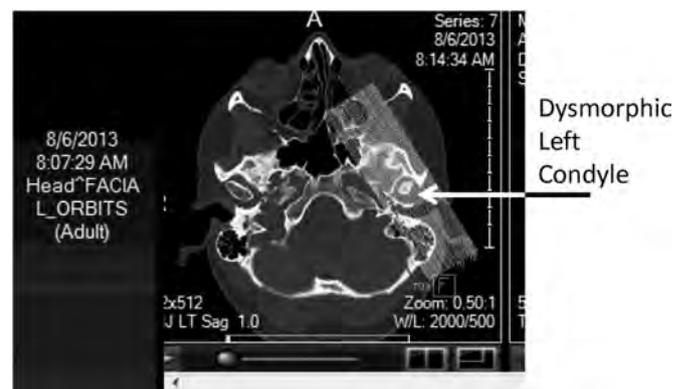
Dysmorphia of the mandibular condyle in an 18 y old Ehlers Danlos Type III patient (a genetic cartilage impairment). This CT-scan allows studying the impairment of the mandibular condyle. Patient misdiagnosed for years: repetitive ankle luxations and temporo-mandibular pain with bruxism, presence of daytime fatigue, some degree of daytime sleepiness, difficulty to concentrate, and mandibular pain. Results of polysomnography: apnea–hypopnea index-AHI = 16.9 events/hour of sleep, lowest oxygen saturation: 89%, flow limitation: 85% of total sleep time.
